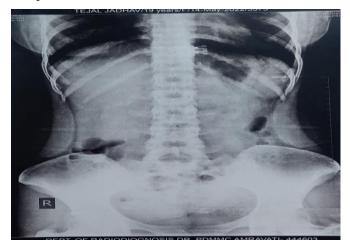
Clear abdominal radiograph suggesting passage of file
